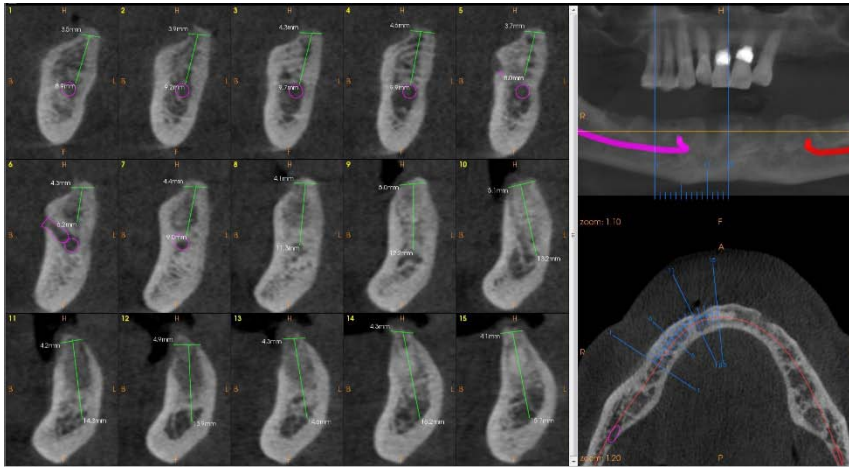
Shows the pre operative CBCT scan of mandibular arch with measurements
